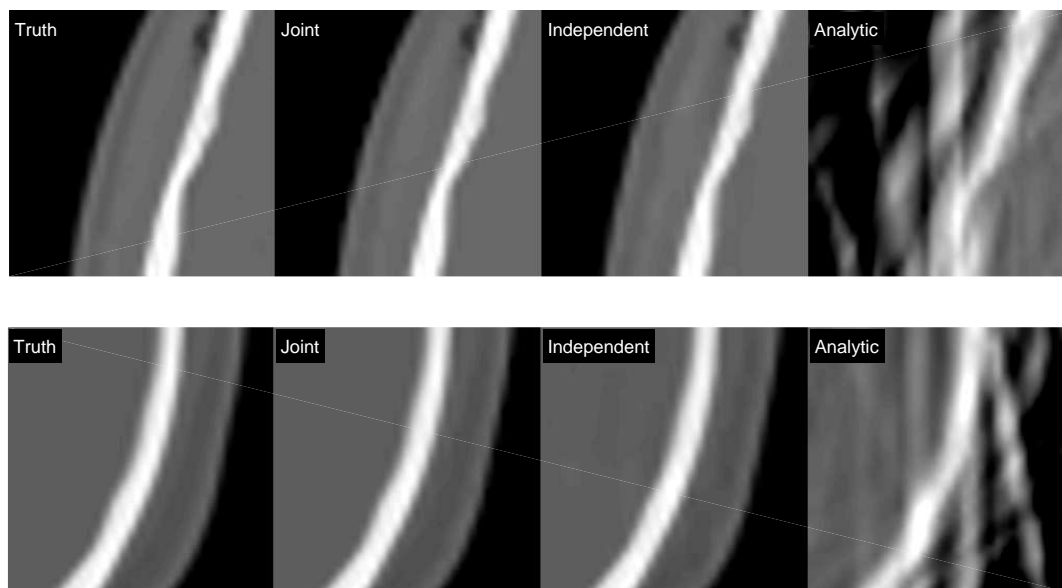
ROI comparison for CT head images with all two ROIs being defined in Fig. 5.16 in red; All ROIs are zoomed in with zoom factor of $8\times$. Display window is $[0 \ 1]$.
